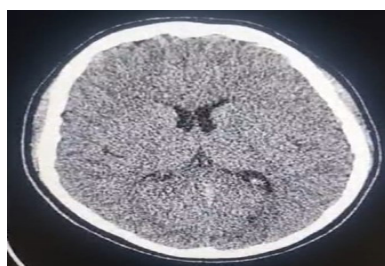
Computed Tomography (CT) upon admission: Demonstrated without organic pathology
